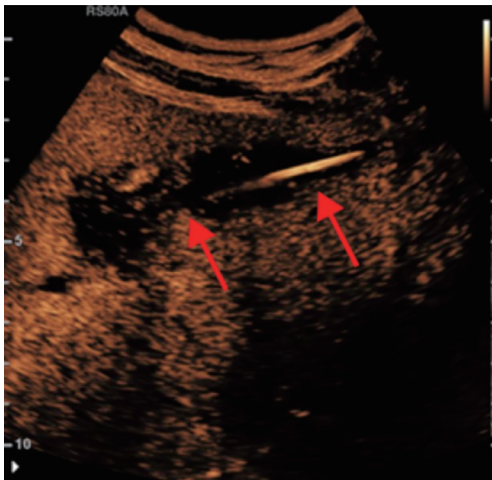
The red arrows point to the lesion. Contrast-enhanced ultrasonography indicated a lengthy hyperechoic area in the left outer lobe of the liver, surrounded by a hypoechoic zone, suggesting the presence of a foreign body associated with infection.
